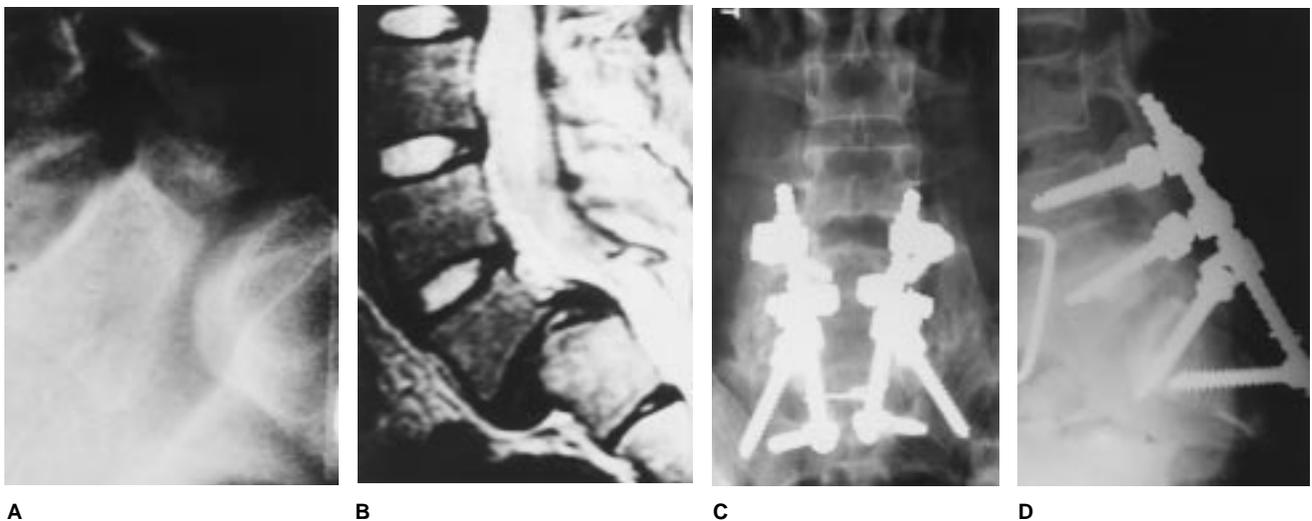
Lateral plain radiograph (A) and sagittal MR image (B) reveal a grade II isthmic spondylolisthesis at the L5-S1 level in a symptomatic 16-year-old patient. Patient underwent a successful decompression, reduction, and posterolateral fusion from L4 to S2 with pedicle fixation, depicted on AP (C) and lateral (D) radiographs.
